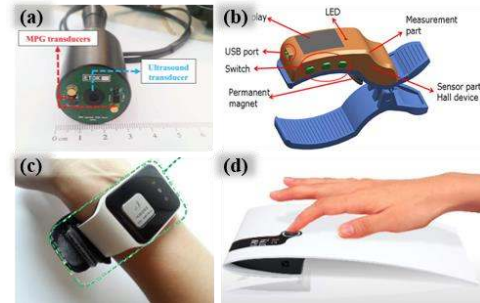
Other cuffless blood pressure (BP) approaches: (a) ultrasound and pulse transducer [70]; (b) magnetic Hall for BP monitoring [94]; (c) tissue informative mechanism for wearable BP monitoring [96]; and (d) phase shift method [98].
